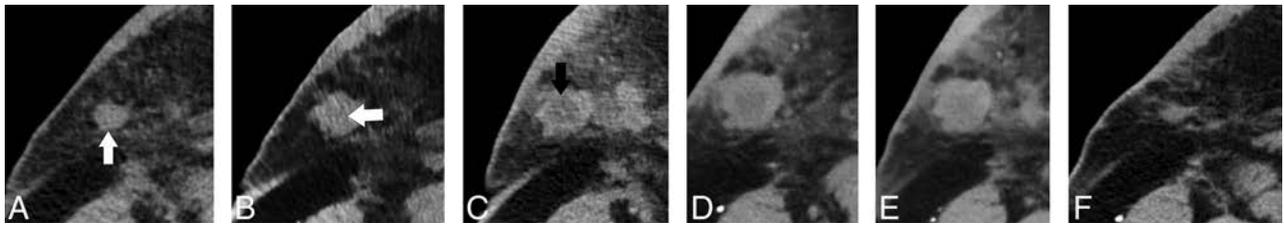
A, Axial contrast-enhanced CT shows a small nodule in the deep right breast/axillary region (*white arrow*). The lesion shows slight central hypattenuation and increased size at 34 days after injection (*white arrow*, B) with the development of frank central necrosis after 72 days (*black arrow*, C). There is a mild further increase in size at 104 days (D), followed by decreased size at 125 days (E) and near complete resolution at 174 days (F).
